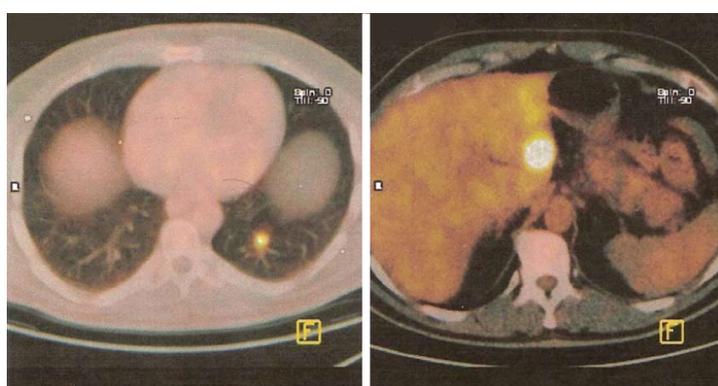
Positron emission tomography/computed tomography imaging showing a pathologic uptake of the tracer in the region of the pancreatic neck and in the left lung from a melanoma.
